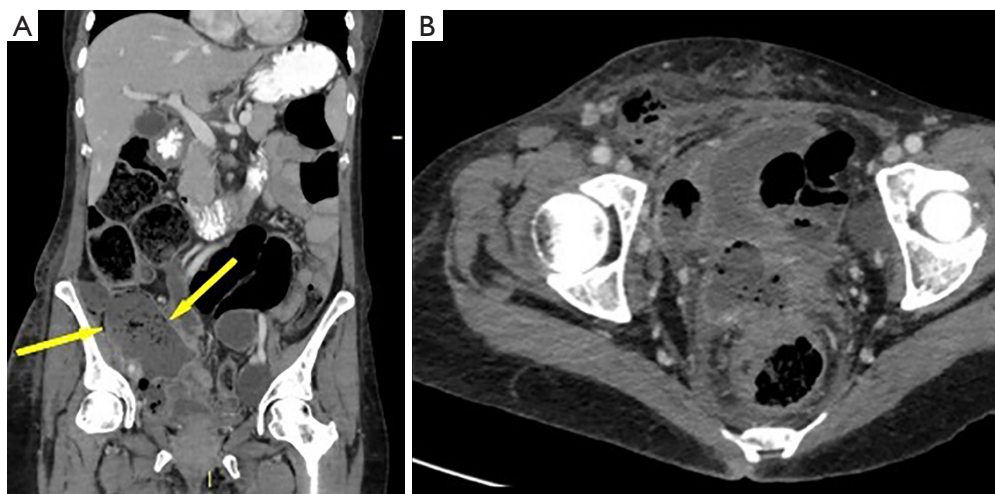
CT-scan imaging revealing the abdominal fecal collection through the right inguinal canal in case #2. (A) Mixed collection of air bubbles in peri-colonic area (filled arrows). (B) Extension of the mixed collection in the right pelvic fossa medial to the external iliac vessels (arrow head) and in the inguinal canal (empty arrow).
